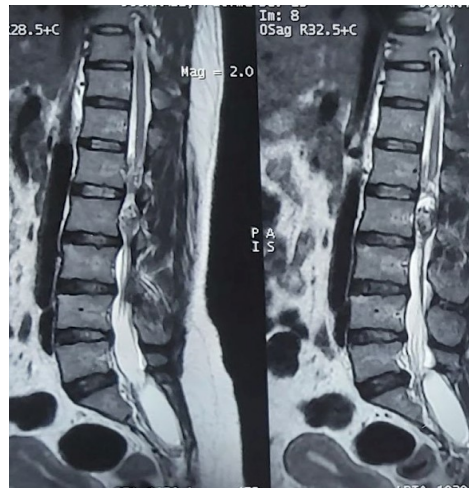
MRI sagittal sections. T2-weighted sequences showing the cyst in the conus medullaris and a sacral meningocele.
